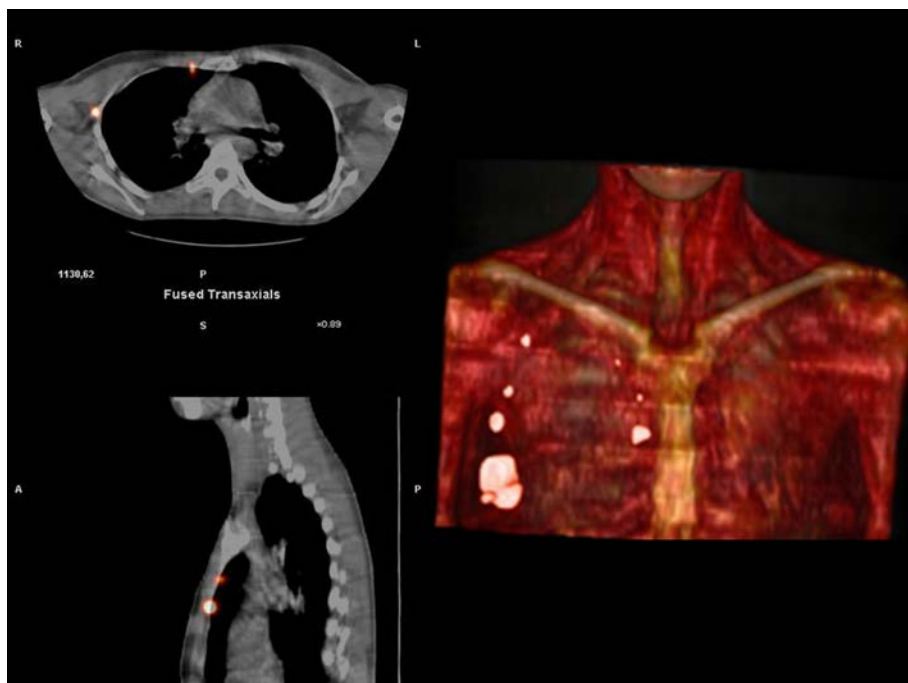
Images obtained of a 38 year old woman with a tumour in her right lower outer quadrant. After injection of 111 MBq of  $^{99m}\text{Tc}$  nanocolloid, planar images were acquired at 30 min and 2 h. Subsequently, SPECT/CT acquisition was started. Fused SPECT/CT images (left panel) in the axial and sagittal axes are depicted, showing uptake in IMN and in the axilla. Volume rendering reconstruction (right panel) provides a precise overview of the location of every SLN with reference to the anatomical background.
